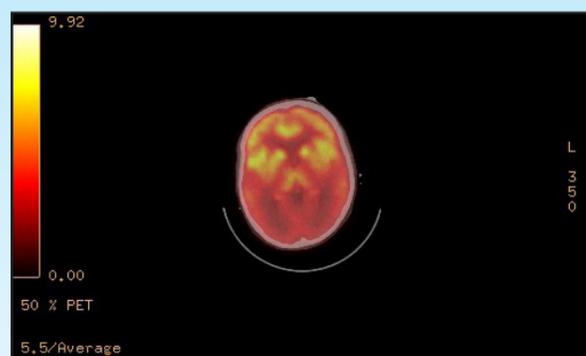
PET-CT of the head demonstrating diffuse photopenia in the parietal and occipital lobes, related to metabolic activity due to ongoing encephalitis.
